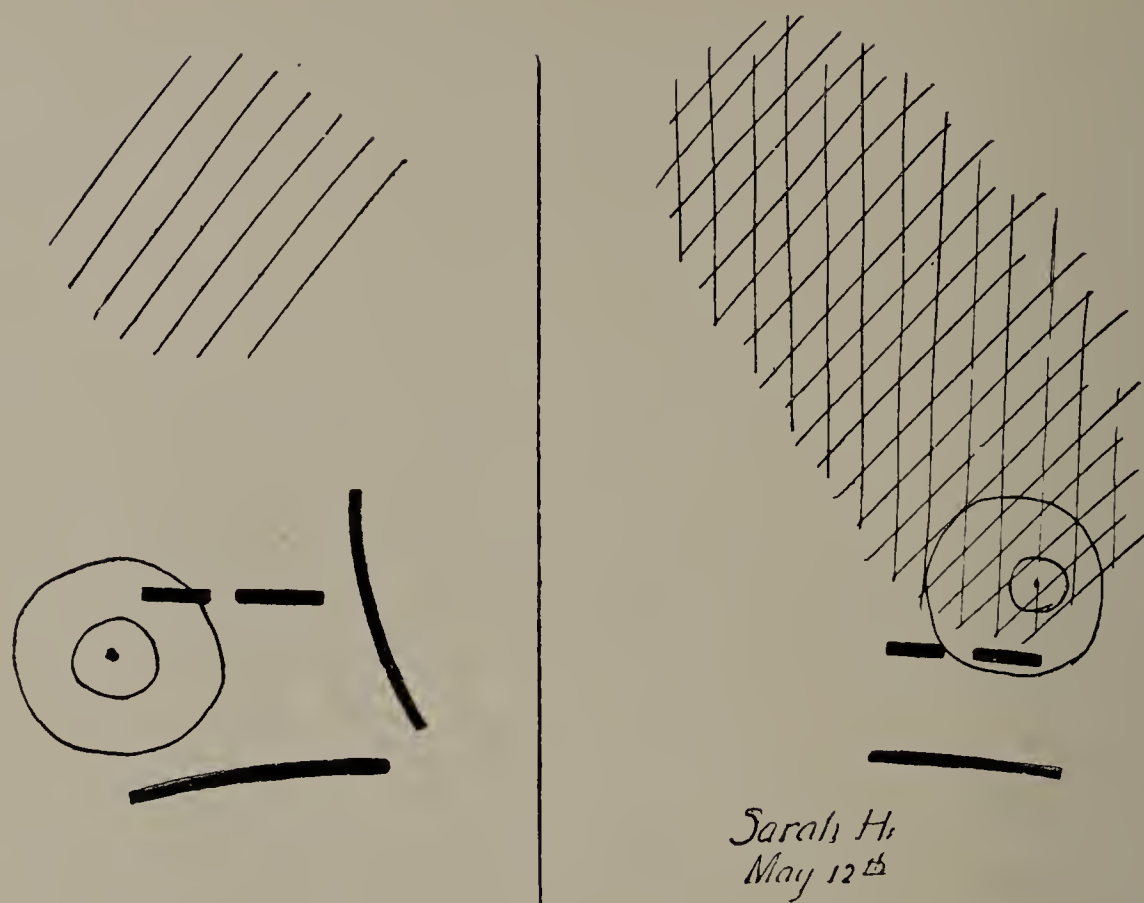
Sarah H. May 12. Third X-ray tracing. Left lung darker than on May 6; excursion of diaphragm reduced to 2.5 centimetres on this side. (One-third life size.)
